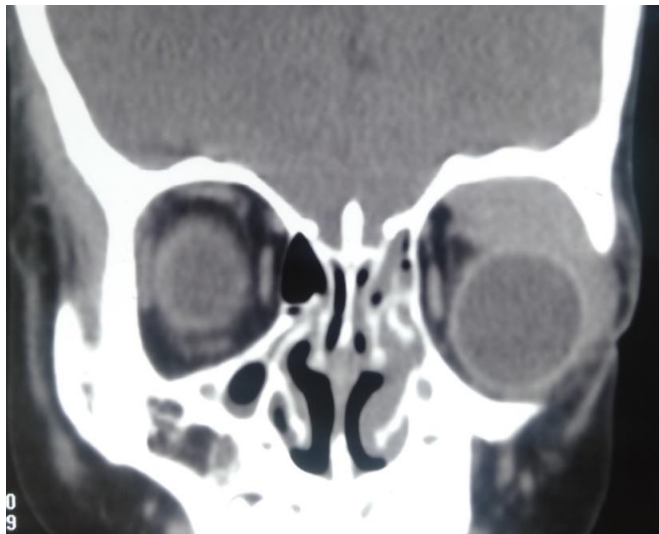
Coronal CT image showing extension of the tumor in the left eye.
